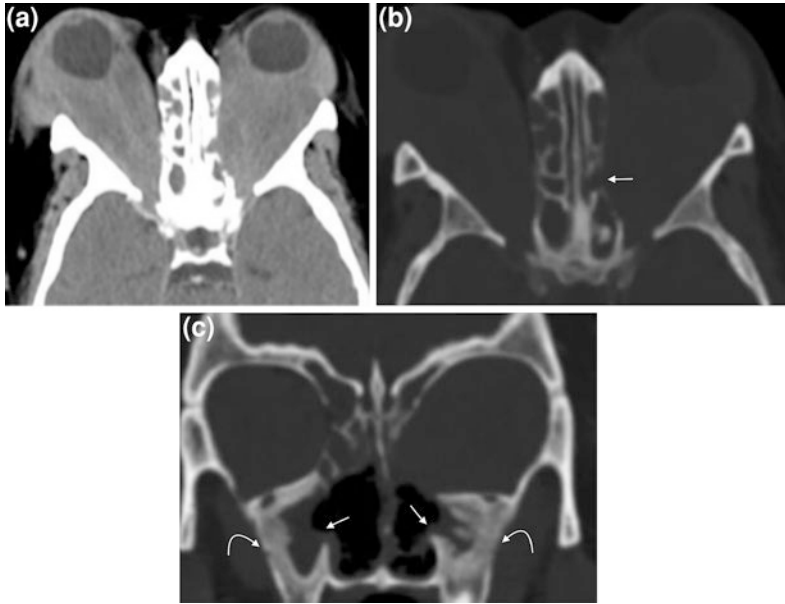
Orbital involvement in a case of granulomatosis polyangiitis on CT a–c Non contrast axial and coronal CT images in soft tissue and bone windows showing bilateral orbital large infiltrative extra and intraconal soft tissue masses that mold to the orbital contour associated with proptosis of the eye globes. The paranasal sinuses show pansinusitis with destruction of medial wall of both maxillary sinuses, left lamina papyracea and nasal turbinates together with perforation of nasal septum, and sclerotic thickening of both maxillary antra lateral walls suggestive of chronic neo-osteogenesis
